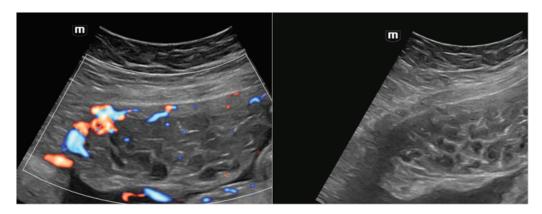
Ultrasound images of placental mesenchymal displasia
